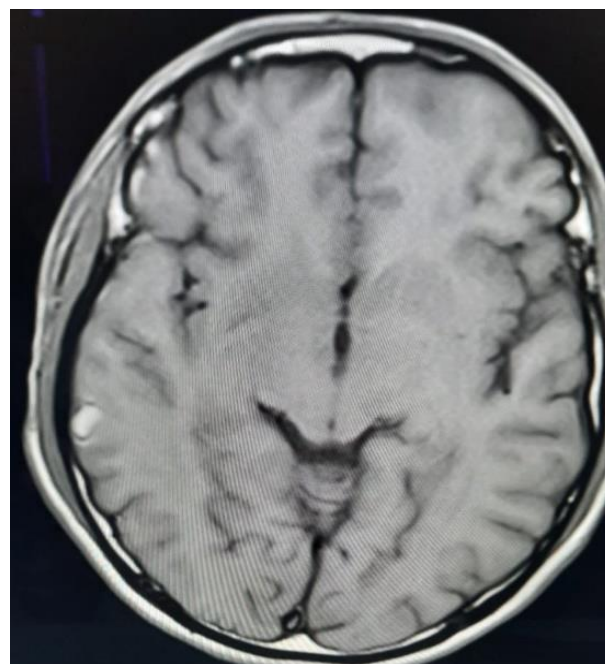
MRI brain, axial section; resolving superficial cortical hemorrhagic contusion in the right temporo-parietal region.
